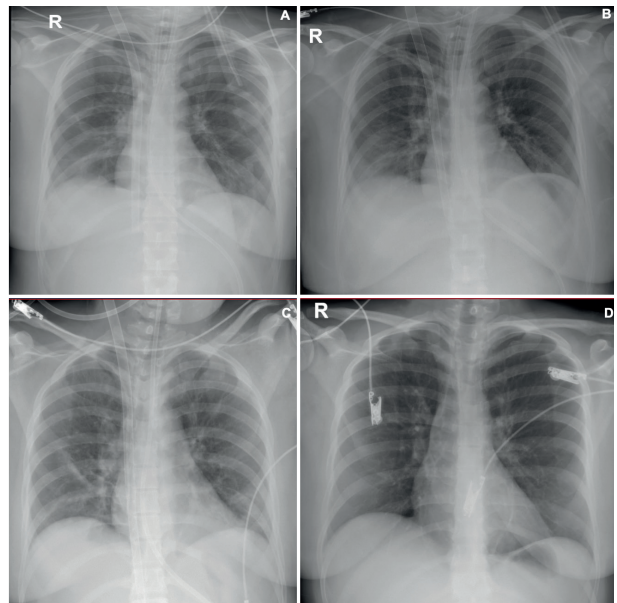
Sequential chest X-ray of case 2. A. thickening of the peribronchovascular sheath, nasogastric tube, ECMO cannula in place and right subclavian catheter with its distal end in the right atrium. There are no areas of consolidation or pleural effusion. B. Veiling of the right costophrenic angle due to a small pleural effusion, with no areas of consolidation. C. Small band of right flat atelectasis, patent airway, presence of ECMO cannula and right subclavian catheter. D. Recovery chest X-ray showing a normal cardiac silhouette, normal pulmonary fields and a normal mediastinum.
